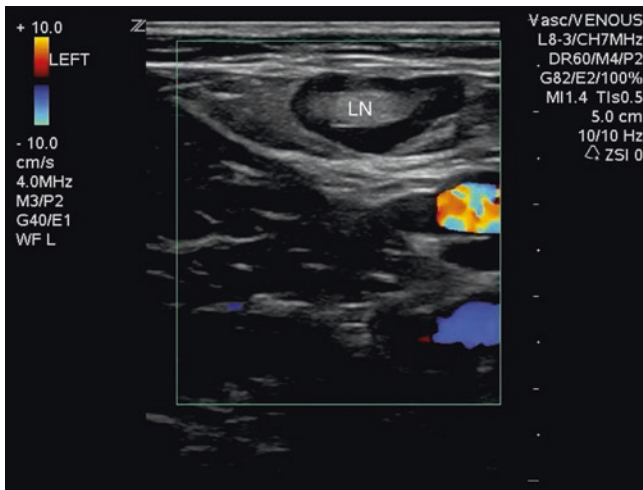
Lymph node (LN) commonly seen while performing lower extremity ultrasound. Lymph nodes will be superficial to the vasculature and demonstrate a hyperechoic center and hypoechoic rim, typically described as a pseudokidney appearance. Courtesy of Christopher Gelabert
